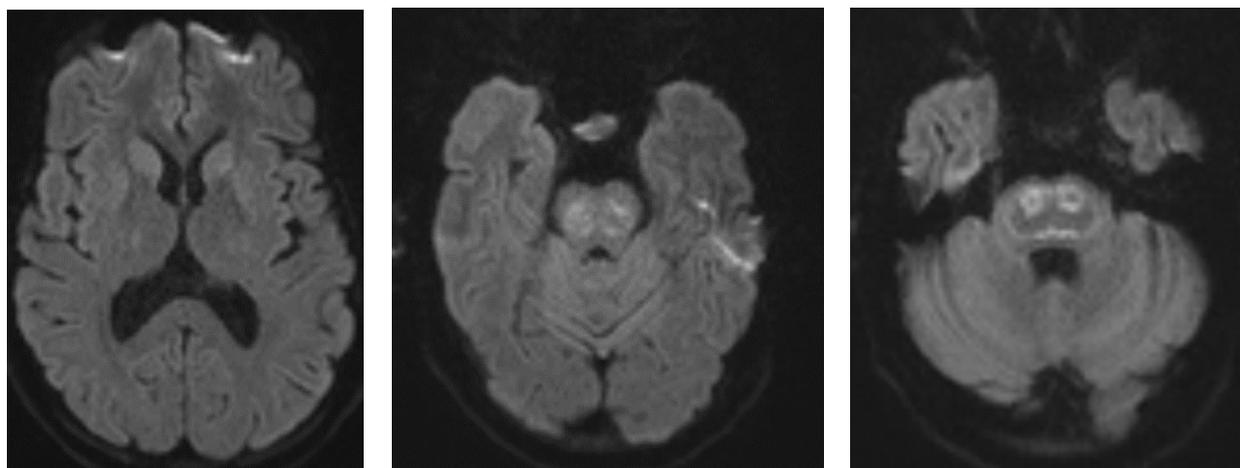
Diffusion sequence: brain MRI showing signal anomalies in Flair hypersignal visible at the frontal cortical level associated with mesencephalic signal anomalies, involving the protuberance, mesencephalic tegmentum, the locus Niger and sparing the red nuclei (arrow)
